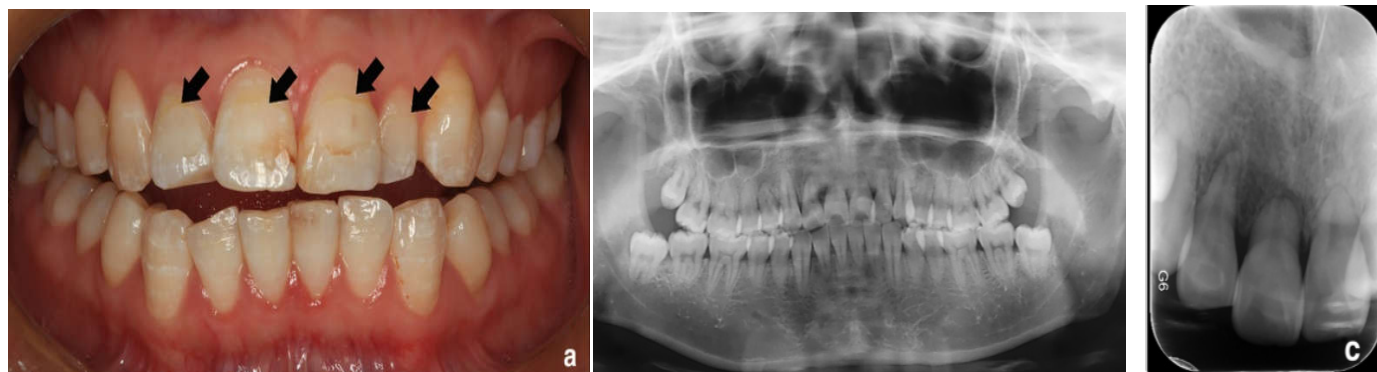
Photograph and X-ray of Case # 7: This is a 27-year-old woman with PPH (22). A: Photograph of the oral cavity showing enamel hypoplasia in the maxillary incisors B: Panoramic X-ray showing the presence of all teeth, with short roots. C: A retro-alveolar of the maxillary incisors showing short roots
